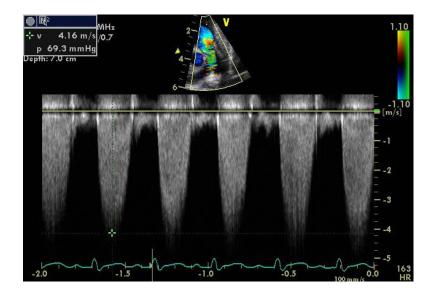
CW doppler of Pulmonary Valve Stenosis
